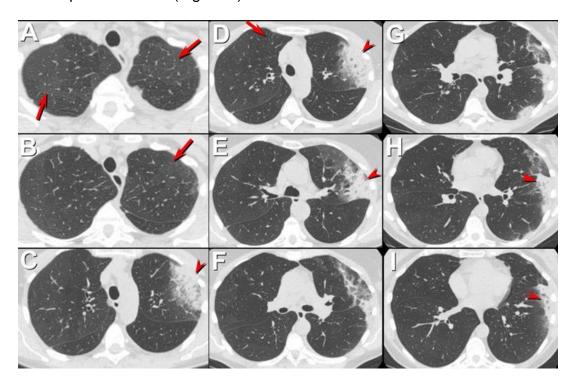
Axial enhanced chest CT displayed in lung windows performed 146 days after presentation.
